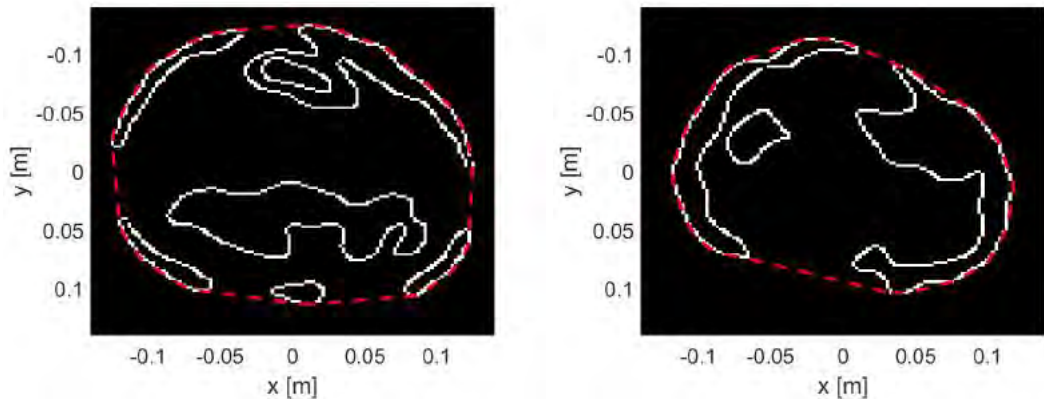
Extracting boundaries of the real part relative permittivity *Low-Permittivity* cluster with ultrasound gel for MRI model 3.
